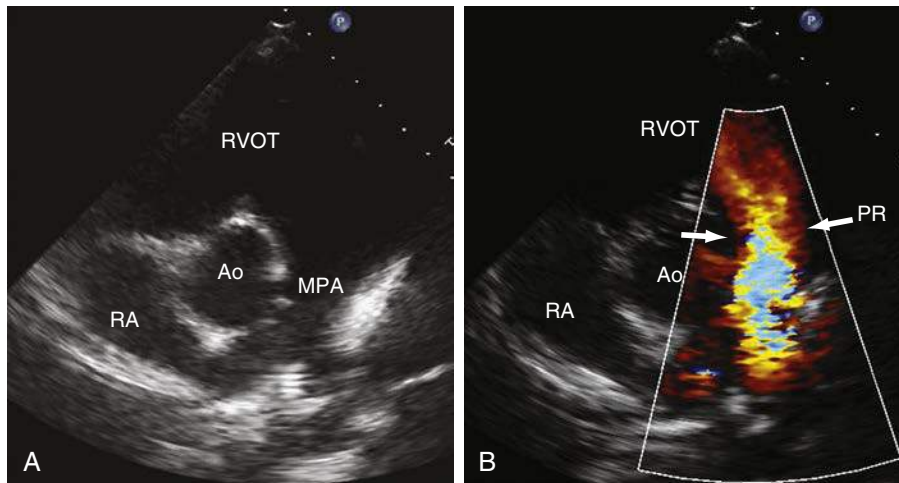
Transthoracic echocardiogram from patient with repaired tetralogy of Fallot. A, Two-dimensional transthoracic echocardiography (2D TTE) from the parasternal short-axis view demonstrates a severely dilated RVOT with a dilated pulmonary annulus and absence of pulmonary valve tissue. B, Color Doppler showing a broad jet of PR (white arrows) originating near a branch pulmonary artery, a feature of severe PR. Ao, Aorta; MPA, main pulmonary artery; PR, pulmonary regurgitation; RVOT, right ventricular outflow tract.
